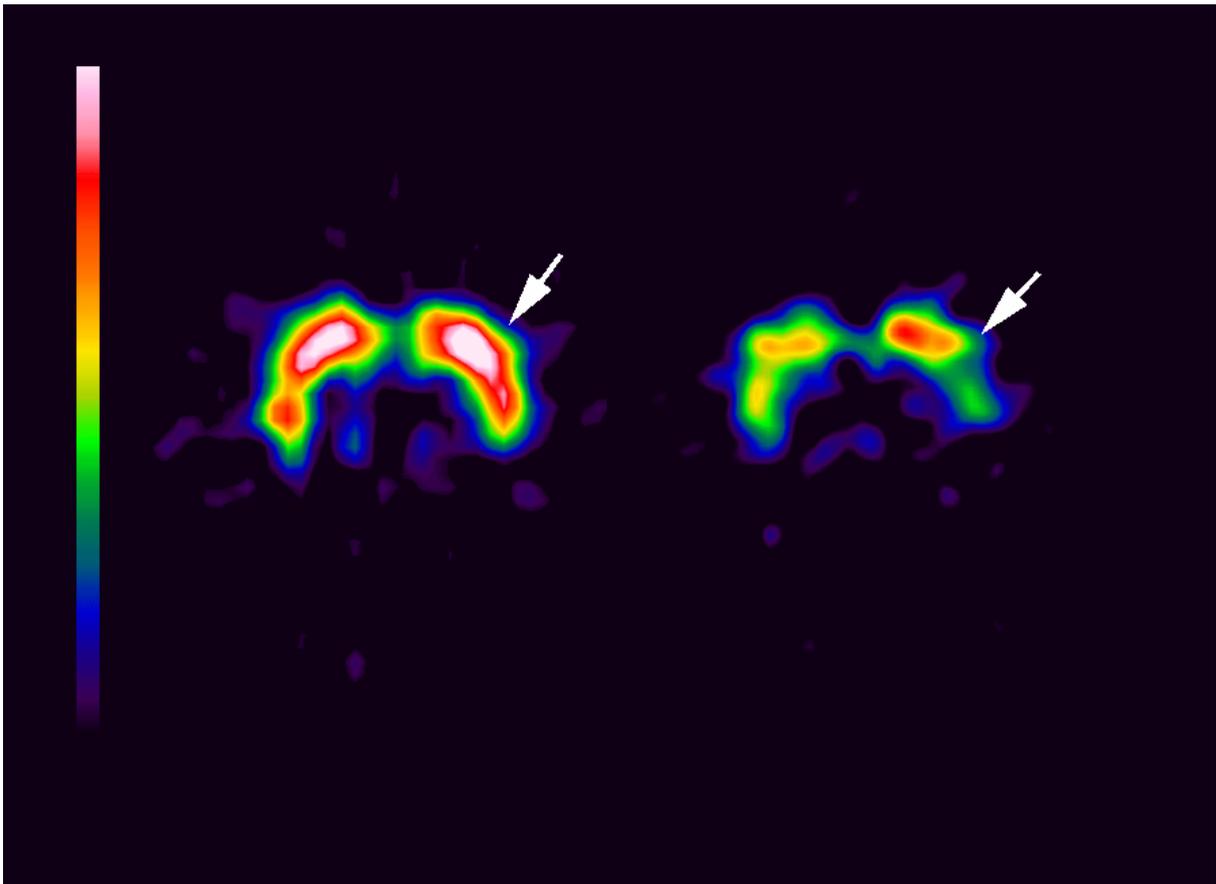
SPECT scans of a depressed patient (left) and a healthy control (right). Arrows indicate the left basal ganglia region. The striatal DAT density is significantly higher in the patient than the healthy control. The increase in DAT density is shown by the brighter colour (white).
